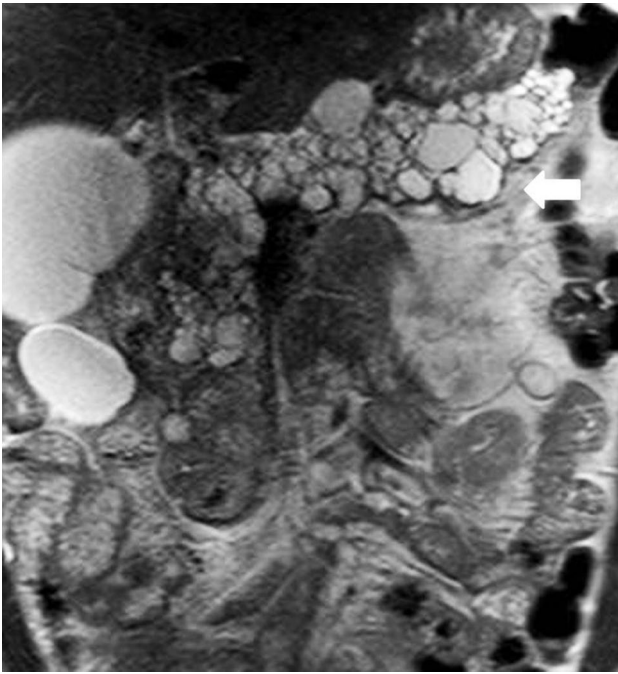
Coronal T2-weighted MR image through pancreas shows multiple cysts with high signal intensity replacing pancreatic parenchyma (*arrow*). This patient has right adrenal pheochromocytoma, right renal cell carcinoma and CNS hemangioblastoma (not shown). All features are consistent with Von Hippel Lindau syndrome
